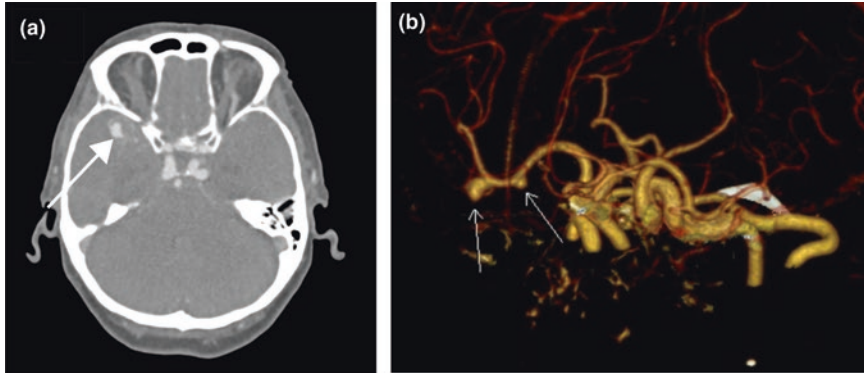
A symptomatic patient found to have two saccular aneurysms arising from the right middle cerebral artery. a Axial CT angiogram image showing one of the aneurysms (arrow). b A 3D reconstruction, both aneurysms are labeled with arrows
